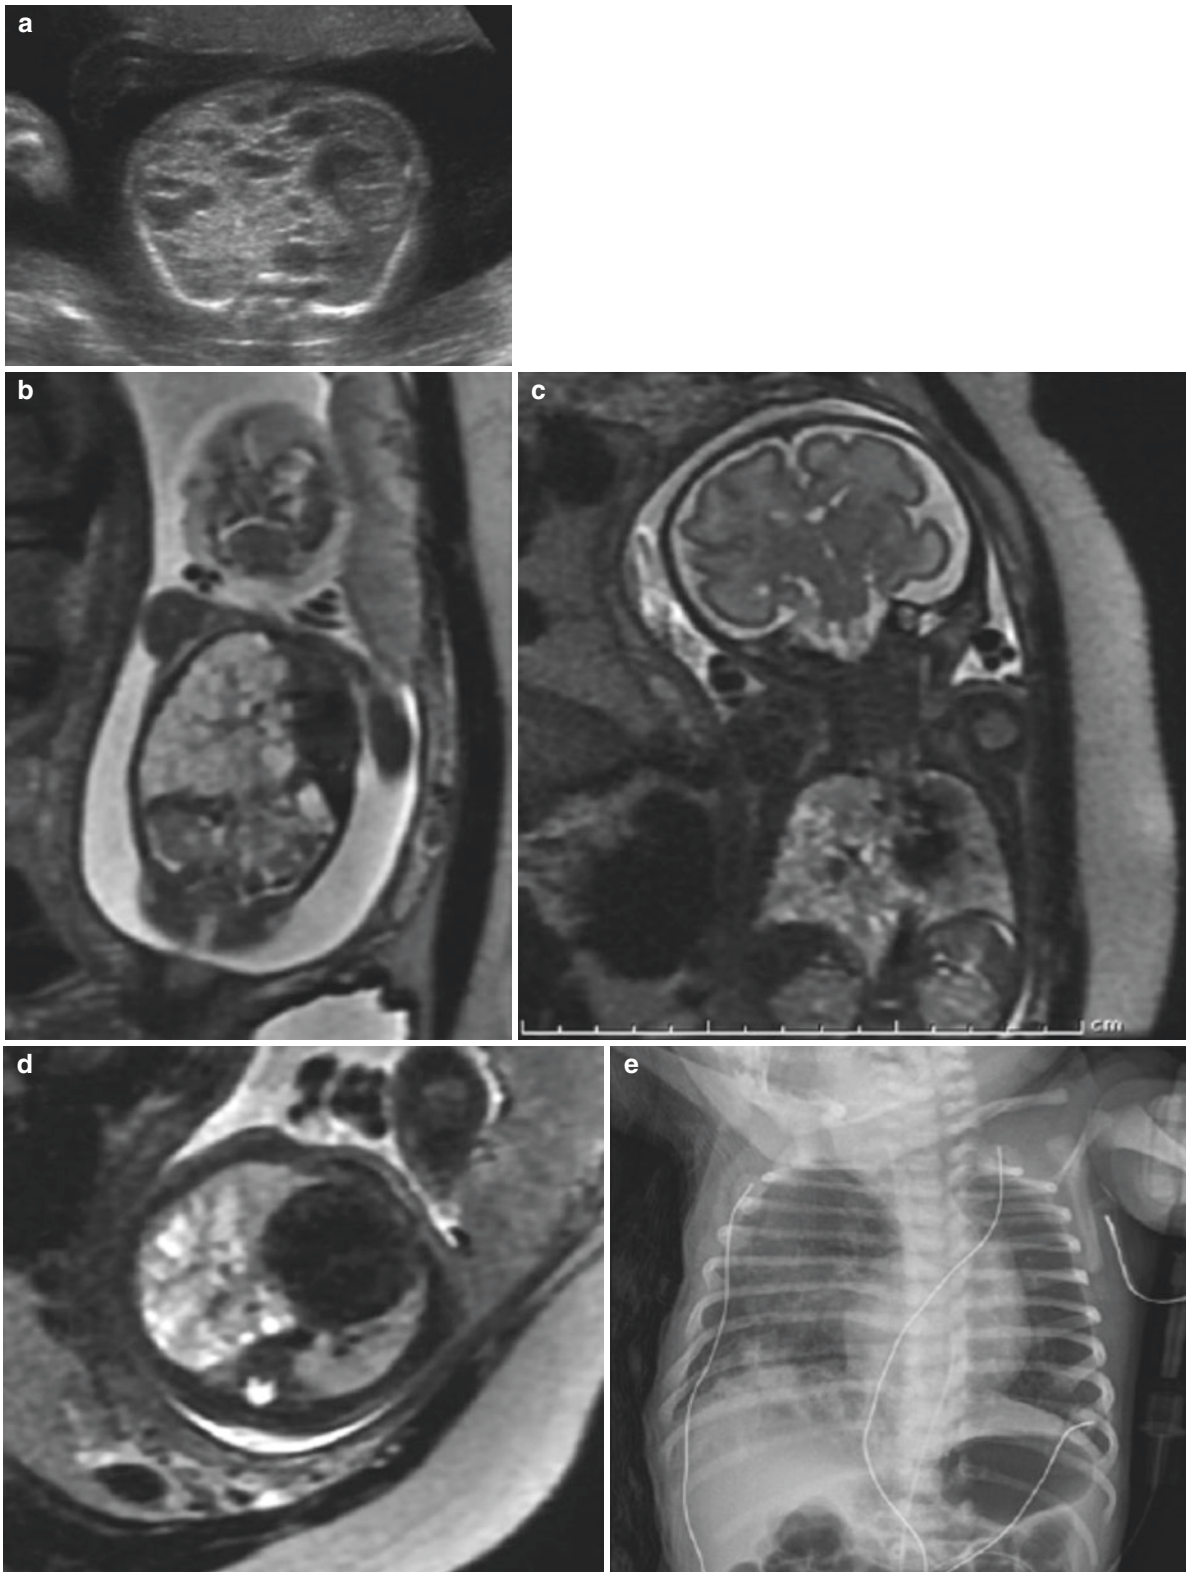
Congenital pulmonary airway malformation. (a) Axial US at 21 weeks gestation demonstrates a large mixed macrocystic and microcystic mass in the right hemithorax with compression of normal left lung. (b) Coronal SSFSE T2w MR image also at 21 weeks confirms the presence of a large multicystic mass in the right hemithorax everting the diaphragm inferiorly and deviating the heart to the left. The CPAM volume ratio (CVR) measures 2.4 high risk for developing hydrops.
